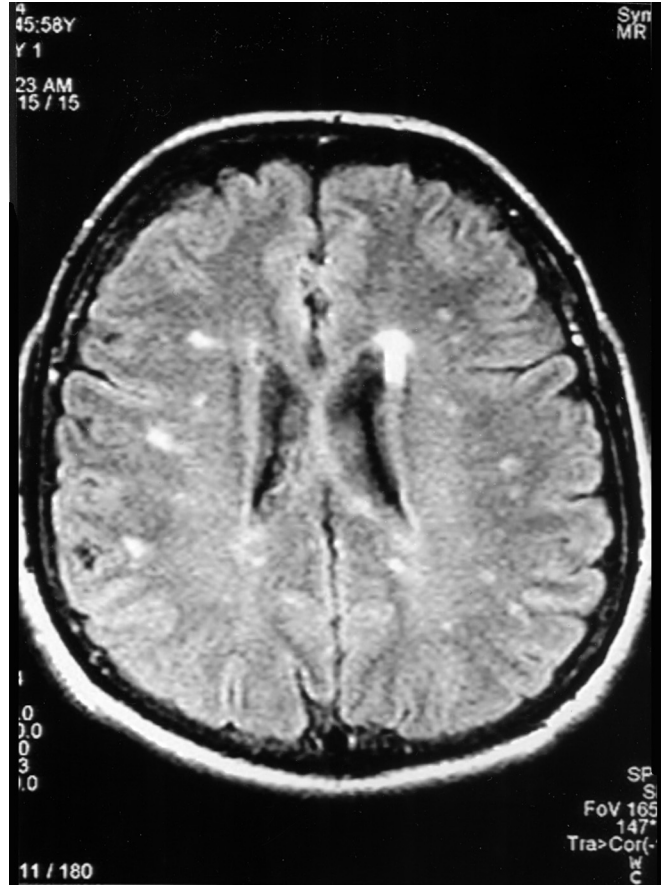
MRI of the brain showing multiple areas of increased signal intensity involving the deep white matter.
